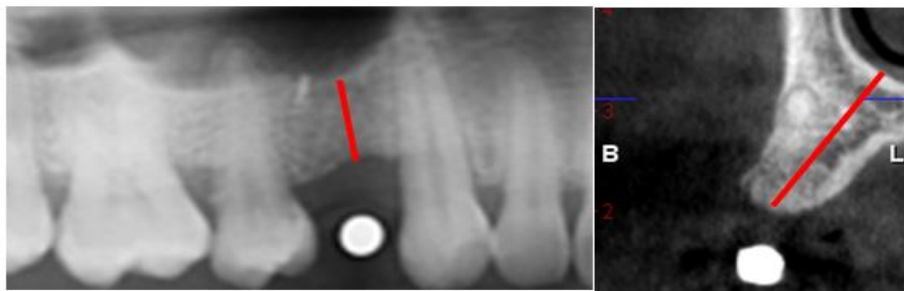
Bone height was measured from OPG & CBCT using Romexis 3.0 IR software and compared
